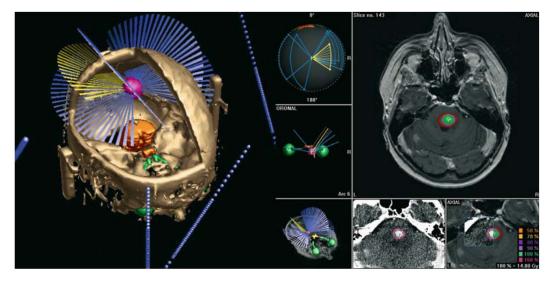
"The images left show the rotational stereotactic technique using six radiation arcs and conical collimators. The images right present the dose distribution for the radiosurgery treatment of a brain stem metastases on MRI (upper) and the CT/MRI image fusion (lower)" [27]
